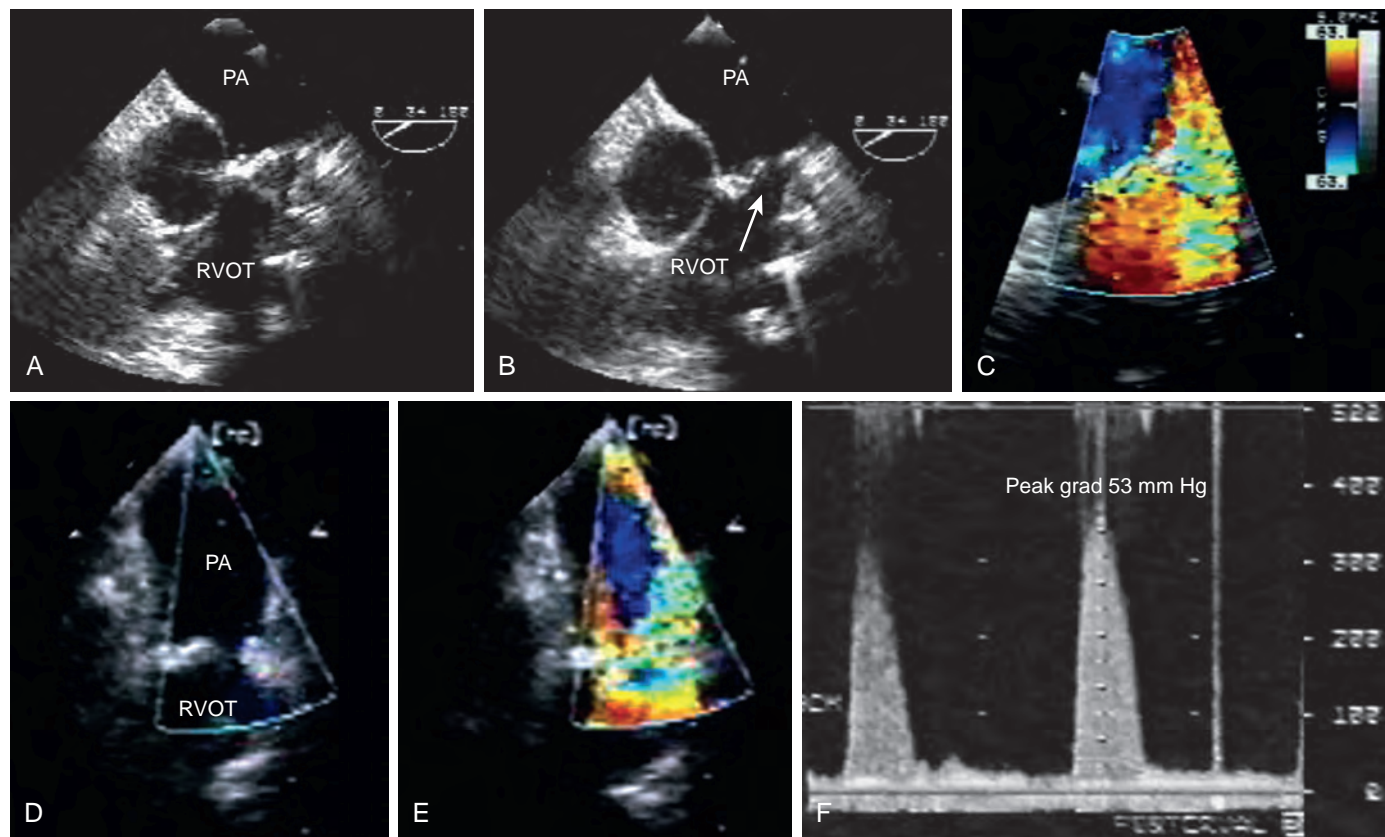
Pulmonary valve stenosis. Images were obtained from midesophageal windows from different angles and probe rotations to visualize flow across the pulmonary valve and to align the Doppler beam with blood flow. (A) and (B) Bioprosthetic valve complicated by obstruction. (C) Color-flow Doppler image of obstruction, showing distorted valve significant turbulence. (D) Thickened leaflets. (E) Abnormal Doppler flow. (F) Continuous-wave Doppler imaging reveals a gradient greater than 50 mm Hg consistent with severe pulmonary valve stenosis. PA, Pulmonary artery; Peak grad, peak gradient; RVOT, right ventricular outflow tract.
